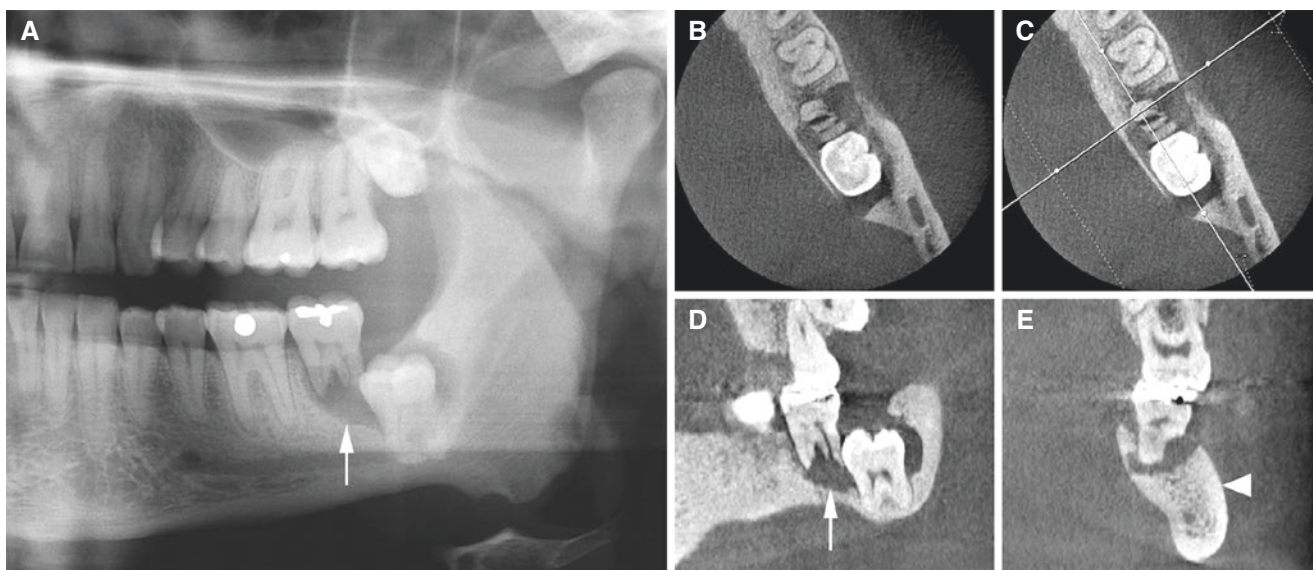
Wisdom tooth with root resorption of the neighboring tooth and associated osteomyelitis, mandible; 38-year-old male with pain in the left mandible. (A) Panoramic view shows pericoronal radiolucency around impacted wisdom tooth and root resorption of the second molar (*arrow*). (B) Axial, (C) axial (with cursor lines), (D) oblique sagittal, and (E) oblique coronal CBCT images show periapical radiolucency
